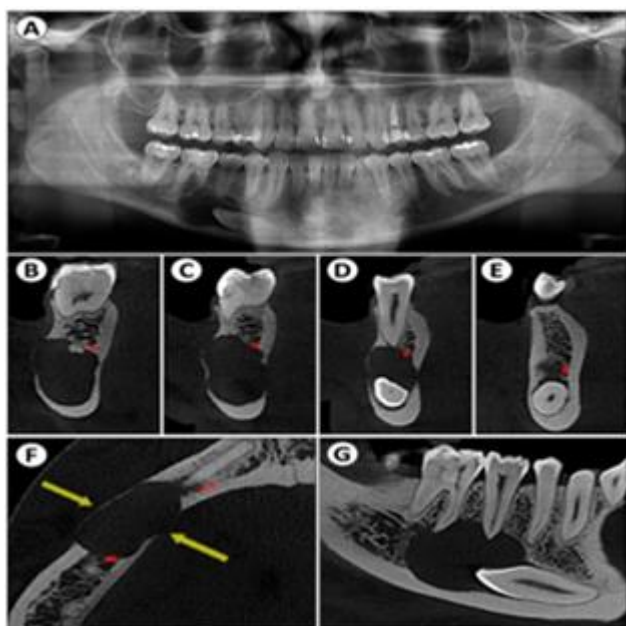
A - Preoperative imaging exam. Panoramic radiograph. B, C, D and E - Cone beam computed tomography, coronal plane. F - Cone beam computed tomography, axial plane. G - Cone beam computed tomography, sagittal plane. Symbols: red, inferior alveolar nerve; yellow arrow, vestibular cortical expansion and lingual cortical disruption.
